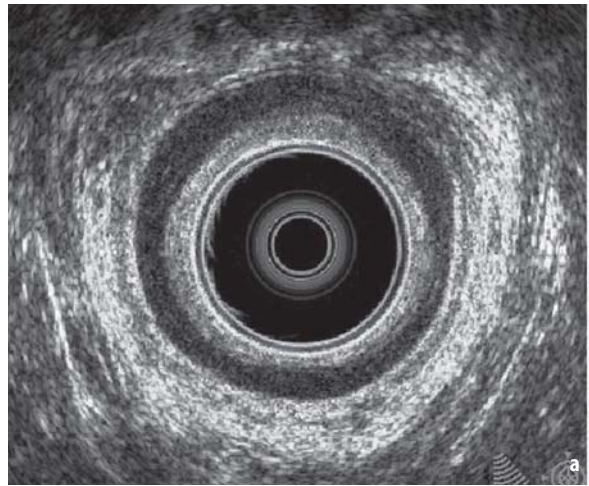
Normal ultrasound anatomy of the deep level of the anal canal demonstrating the puborectalis. Anteriorly, a thin arc of muscle from the deeper part of the sphincter may be seen in males (a) whereas the deep part of the external sphincter is not recognisable in females (b)
